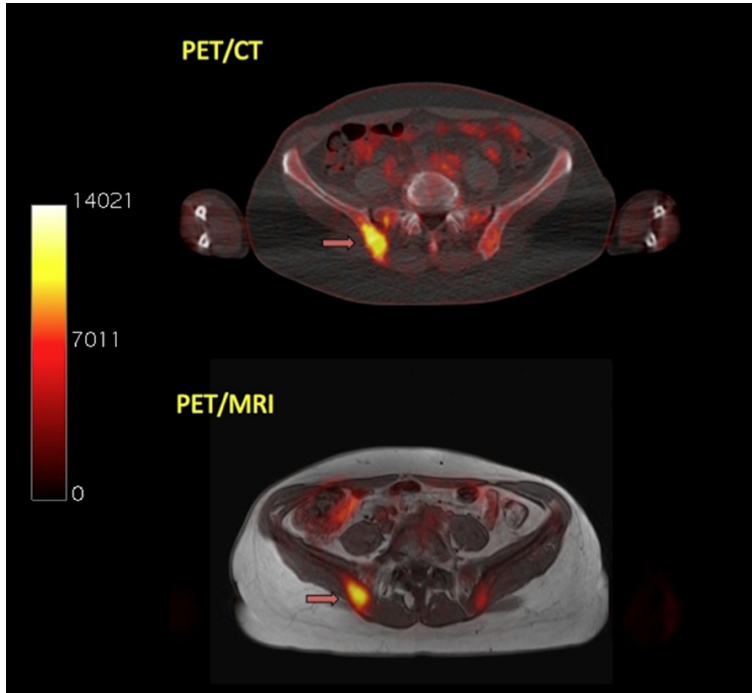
Transaxial PET/CT (upper row) and PET/MRI (lower row) images of a MM patient referred to our department for initial evaluation of extent of bone involvement. A MM-suspicious lesion is depicted in the right iliac bone in both systems. The lesion has the following values in PET/CT: $SUV_{average} = 5.5$ and $SUV_{max} = 7.1$. The respective SUVs in PET/MRI are: $SUV_{average} = 4.2$ and $SUV_{max} = 6.5$. The values of the scale bar refer to Bq/ml.
